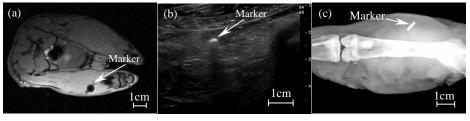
Axial images of marker in rabbit thigh. (a) MRI, (b) Ultrasound image, (c) X-Ray image
